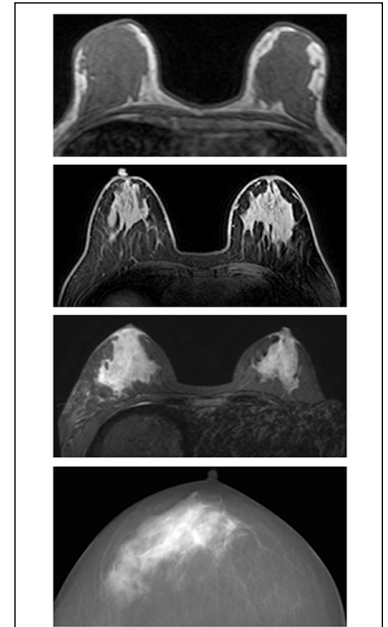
MRI acquired using three different sequences that show different skin contrast. The bottom image shows a mammogram without skin contrast.
